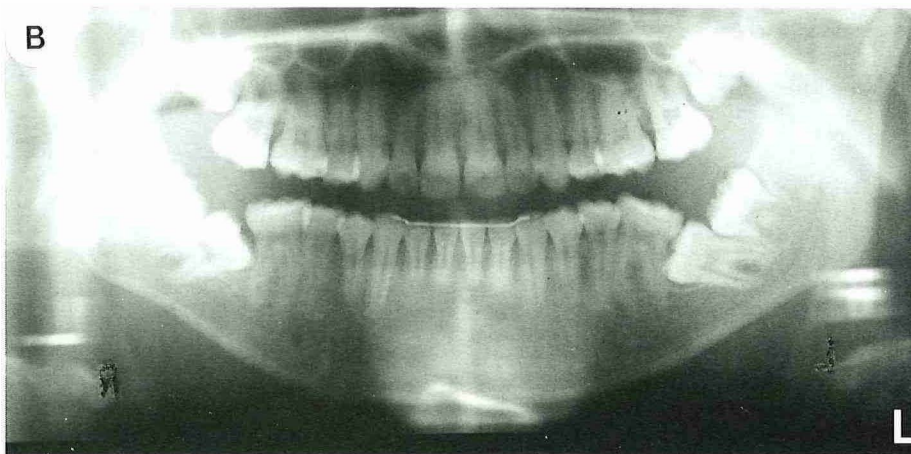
A Orthopantomogram of a 10-year-old female showing normal position of the germs of the second molars in the mandible. B Orthopantomogram of the same female 5 years later showing impaction of the second molars in the mandible.
